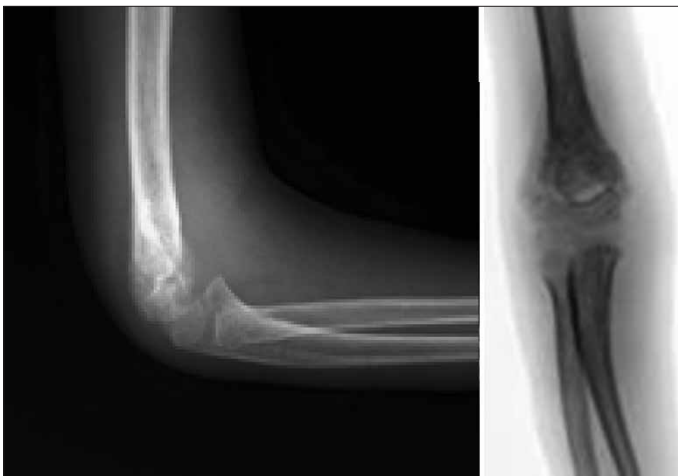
Postoperative 4th week X-rays (AP and lateral)
